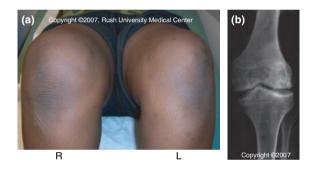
Chronic synovitis and arthropathy. (a) Chronic synovitis of the right (R) knee is typified by a warm and swollen joint with reduced range of motion but no pain with palpation or motion. Palpation of the joint margins and patella are obscured by the spongy synovium, and muscle atrophy is present. (b) Radiograph of the knee showing narrowing of the joint space, erosions at the margins, sclerosis, osteoporosis, a widened intra-condylar notch and cyst formation.
